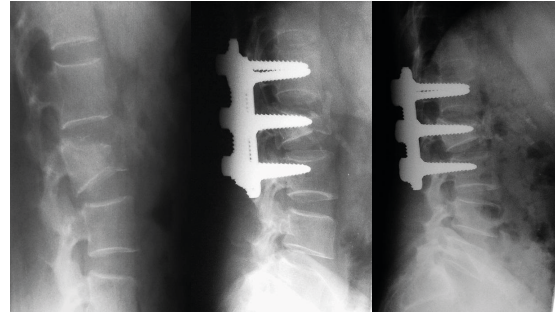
Radiographic study of unstable L3 burst fracture pre-operative, post-operative undergoing posterior short segment pedicular fixation with intermediate screws and follow up images .
